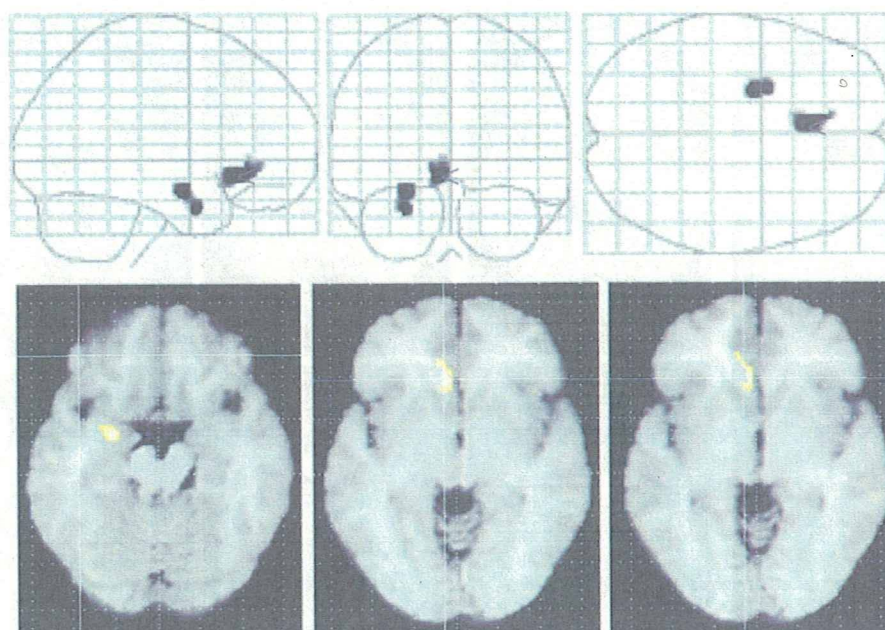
Increased volumes in schizophrenics as compared to controls. *Top:* The SPM  $\{t\}$  is displayed in a standard format as a MIP. Patients with schizophrenia showed a significantly increased volume of the CSF space. *Bottom:* The SPM  $\{t\}$  is displayed onto axial T<sub>1</sub>-weighted MR images. A significantly increased volume of the CSF space such as the lateral ventricle, sylvian fissures and the interhemispheric fissure was noted.
